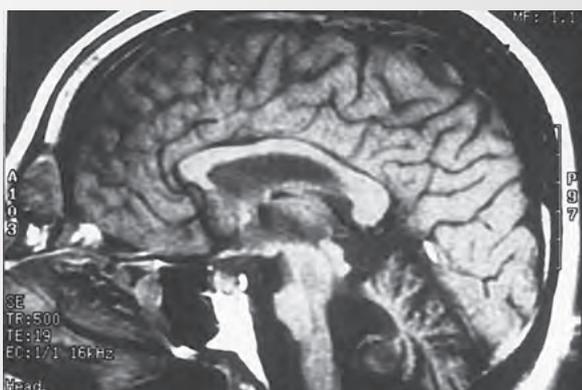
Magnetic resonance image of the head in the sagittal plane in a patient with spinocerebellar atrophy type 3.
